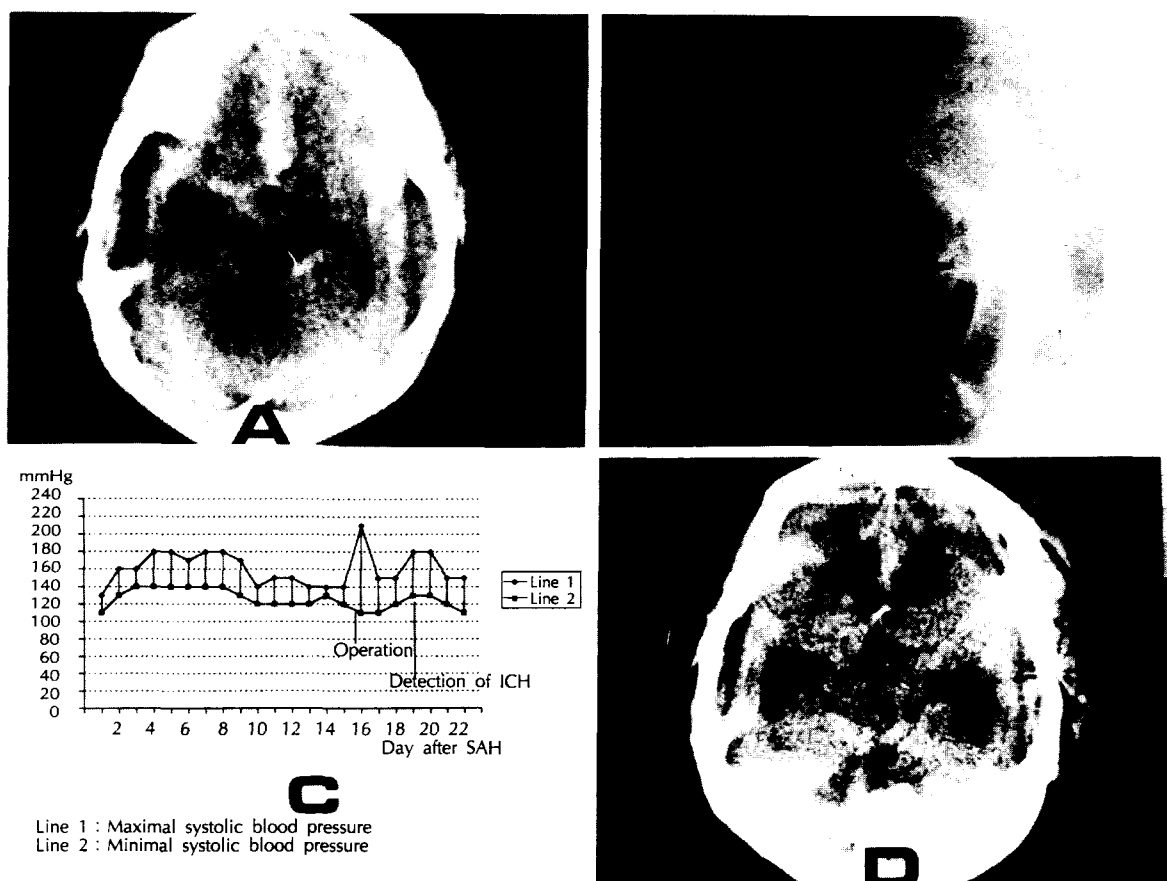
A) Brain CT demonstrates thick blood in all of the basal cisterns.
